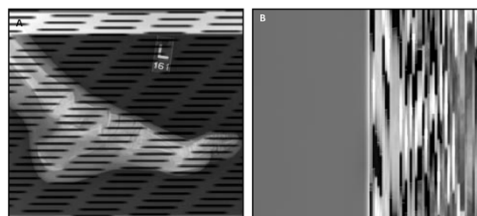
Operator error. This axillary shoulder was exposed through the back of a cassette. Artifact remedy: be sure radiographers are well educated about how to use the entire computed radiography system.
